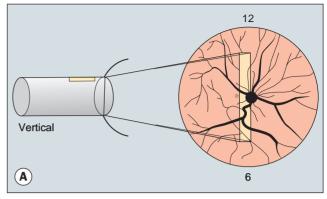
(A) Technique of ultrasonography; (B) B-scan ultrasonogram showing retinal detachment (*Courtesy of P Terry*)
